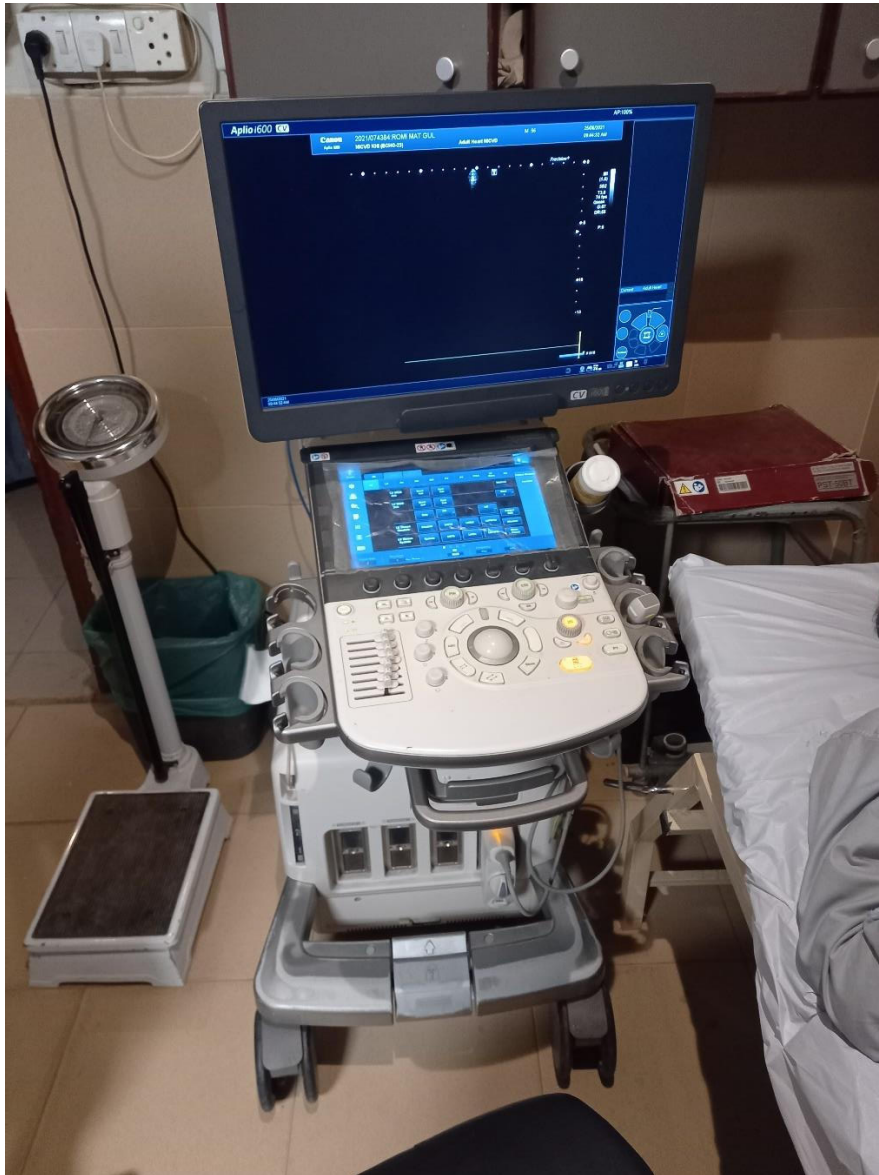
Canon Aplio i600 Echocardiography Machine used in Transthoracic Echocardiography Department at NICVD, Karachi
